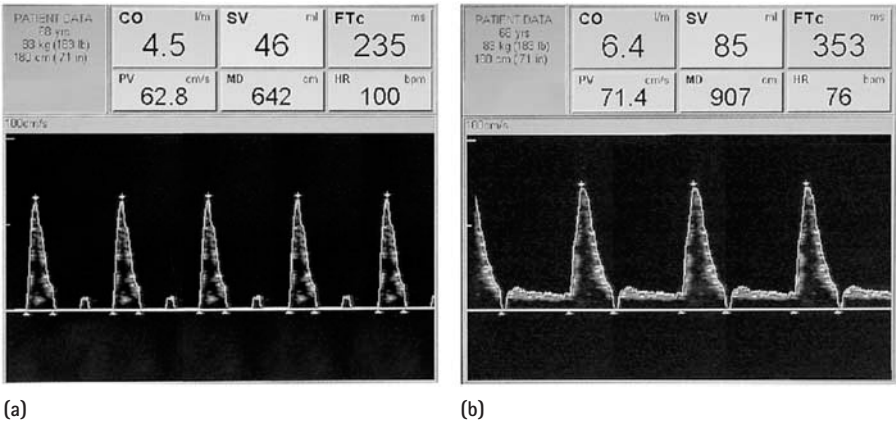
Transoesophageal Doppler monitor screen demonstrating a patient: (a) with hypotension due to hypovolaemia. In this patient, the SV is relatively low (46 ml) and is associated with low FTc (235 ms) and the waveform can be seen to be peaked and narrow suggesting that flow is only occurring in the earliest part of systole. HR is also elevated; however, the PV is maintained at the near-normal for this patient suggesting poor contractility is not a problem. (b) following fluid resuscitation. After appropriate volume loading, the CO and SV have improved substantially with a reflex fall in HR. FTc is now at the normally targeted value (350–400 ms) and the waveform looks wider and fuller. PV has increased slightly showing that the heart was capable of better contractility with increased preload.
